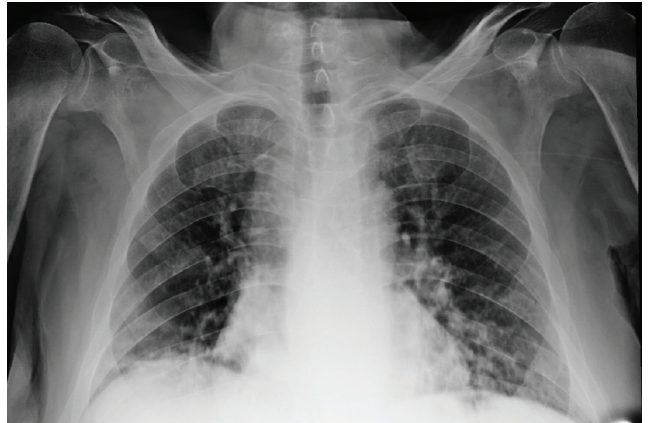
Chest radiograph taken when the patient was discharged
